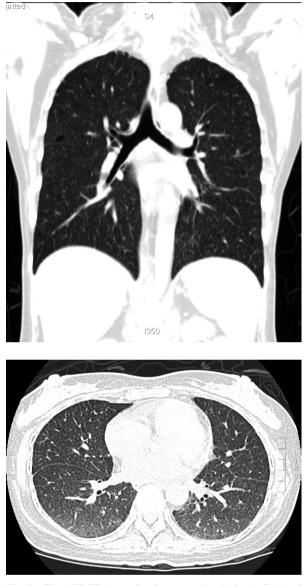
Chest HRCT (coronal and cross-sectional views) disclosed diffuse small lung nodules and interstitial opacities
